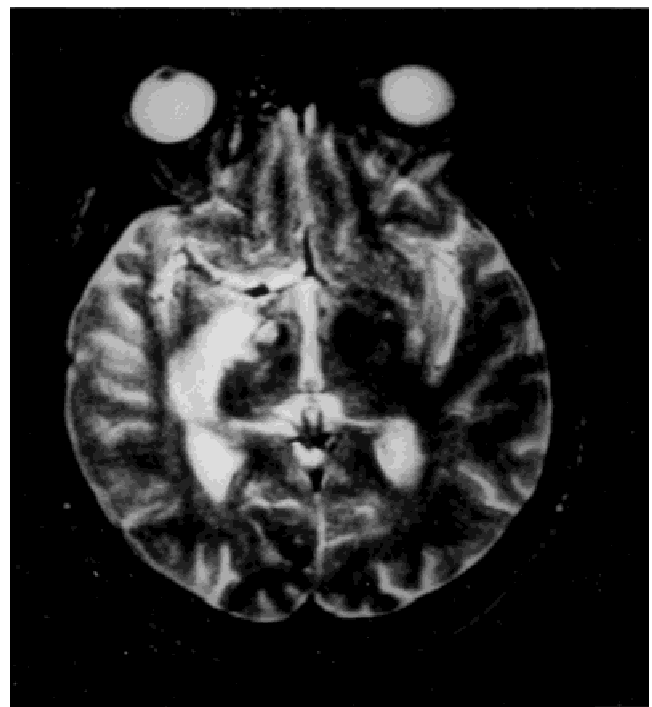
MRI findings. Axial T2 section of the patient, showing hyperintense signal changes in the right posterior limb of the internal capsule and anterior thalamus.
